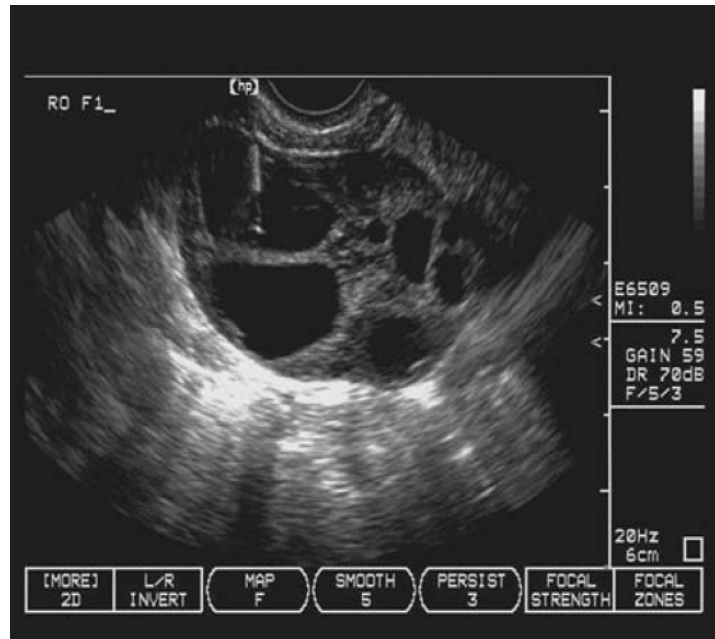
Ultrasound image taken during oocyte retrieval. The highly echogenic band around the distal end of the needle and the tip of the follicle aspiration needle are visualized in the superior-most follicle. The needle is maneuvered within the ovary to aspirate all follicles (*Abington Reproductive Medicine, Gladstone, New Hersey, 2002*).
